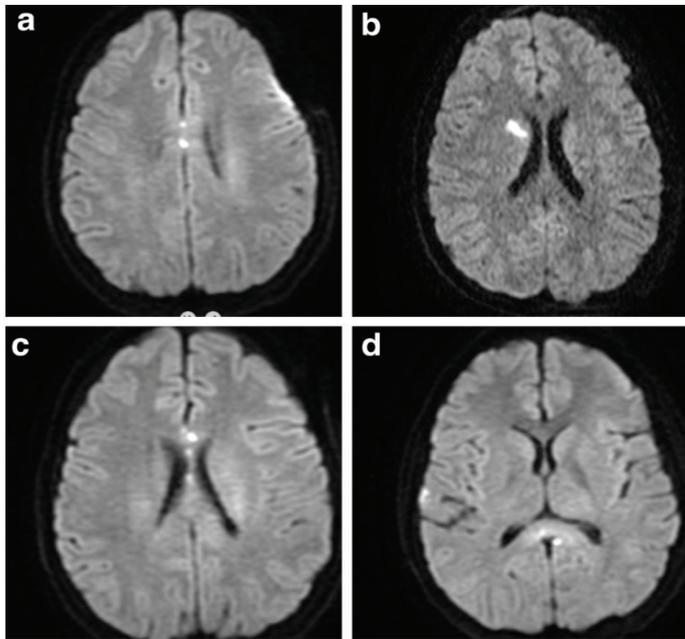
a-d) Diffusion-weighted MR images of 4 different patients suffering from a diffuse axonal injury
